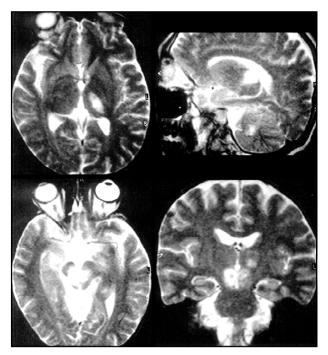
Cranial MRI (T2-weighted) showing hyperintensities in the left thalamus (a, b), cerebellum (b) and midbrain (c, d).
